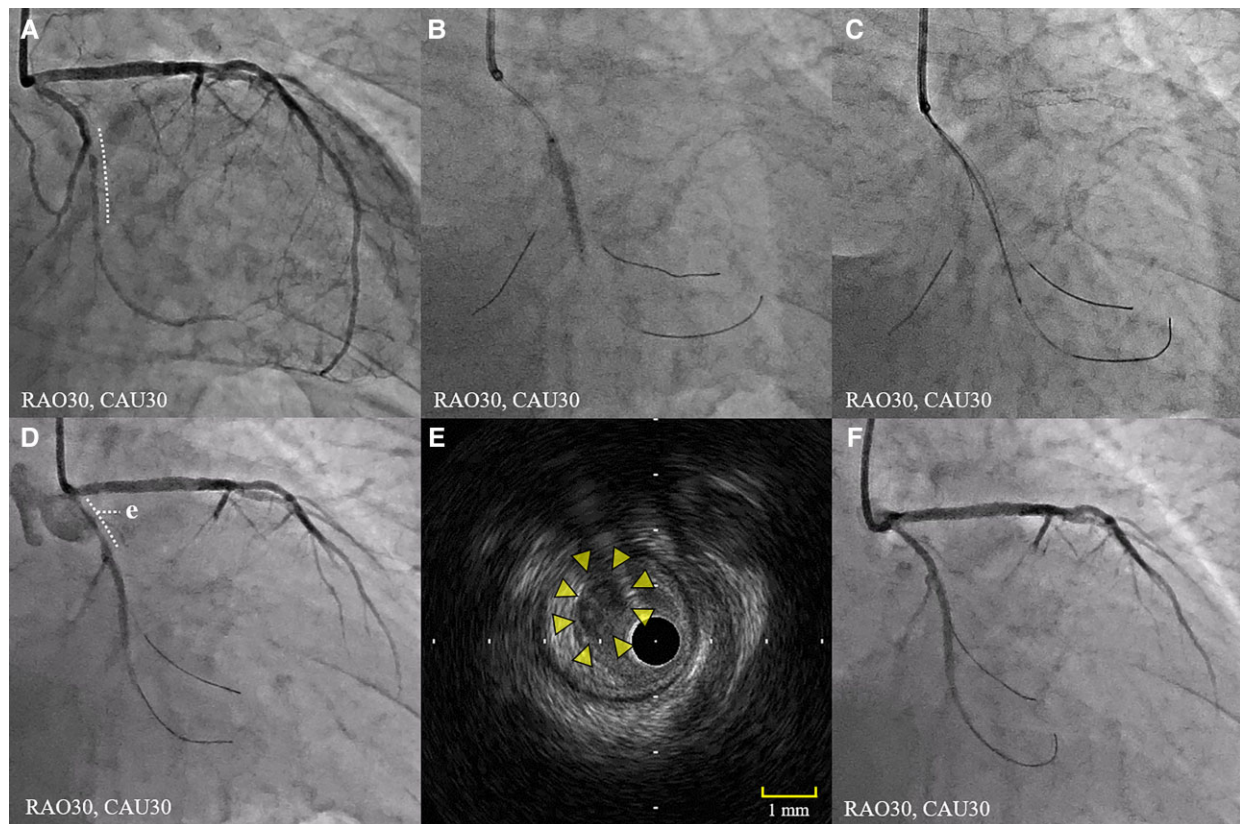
Coronary angiogram: (A) pre-percutaneous coronary intervention for the mid-left circumflex artery (LCx) stenosis (dotted line), (B) stent implantation, (C) optical coherence tomography using low-molecular-weight dextran, (D) newly developed luminal narrowing of the proximal LCx. (E) Intravascular ultrasounds suggesting coronary thrombus without plaque rupture (arrowheads). (F) Coronary angiogram post-improved LCx flow.
